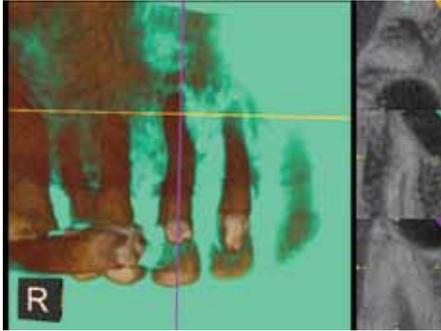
Preoperative CBCT examination revealed the apical branch that came off of the main system
